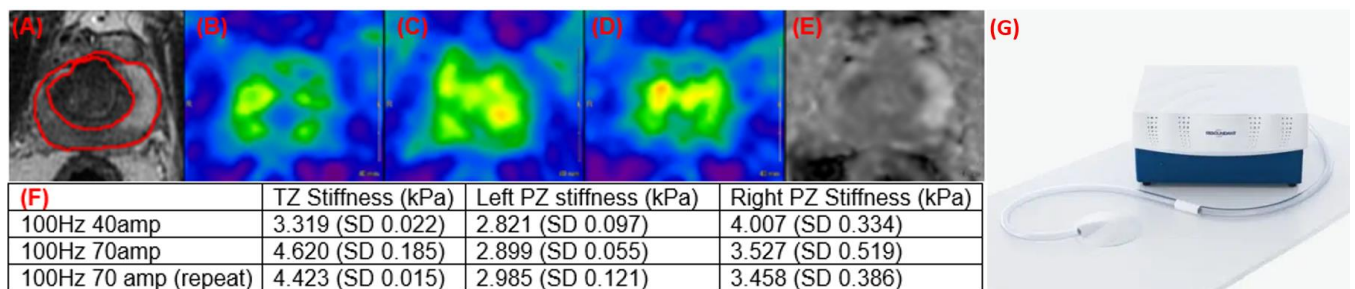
Axial T2W (A) and magnetic resonance elastogram (MRE) stiffness maps of the prostate midgland, at the level of the verumontanum. The 3 MRE stiffness maps were obtained at 100Hz 40 amp (B) and 100Hz 70amp (test-retest) (C-D). Abnormally dark right peripheral zone compatible with prostatitis (negative DWI/ADC) (E). Average region-of-interest stiffness calculations are shown in (F). MRI compatible active driver used for MRE.
